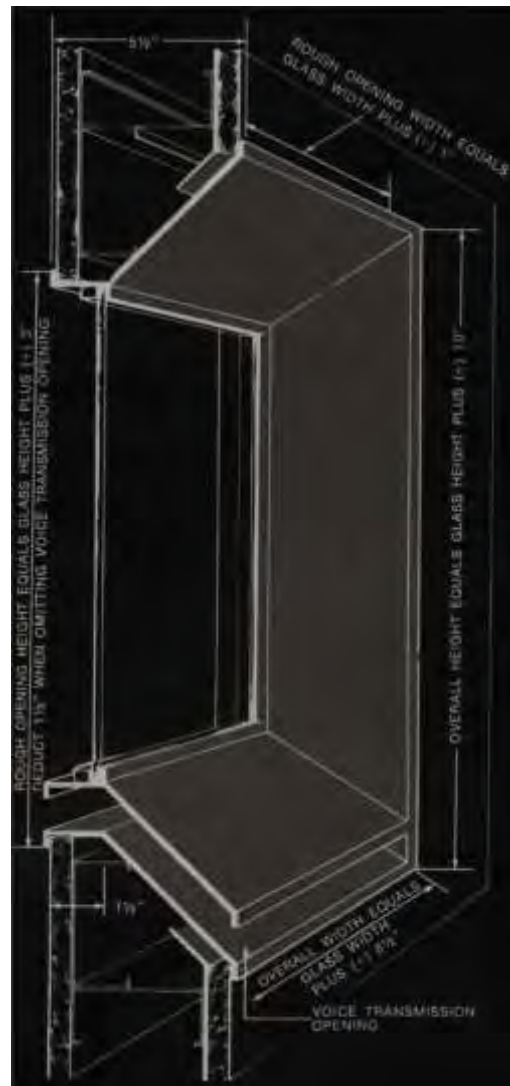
MRI- room shielding details. ETS. LINDGREN an ESCO company, MRI Shielding, Glendale heights, IL 60139, Sep 2009, Available : <http://www.ets-lindgren.com/> .
